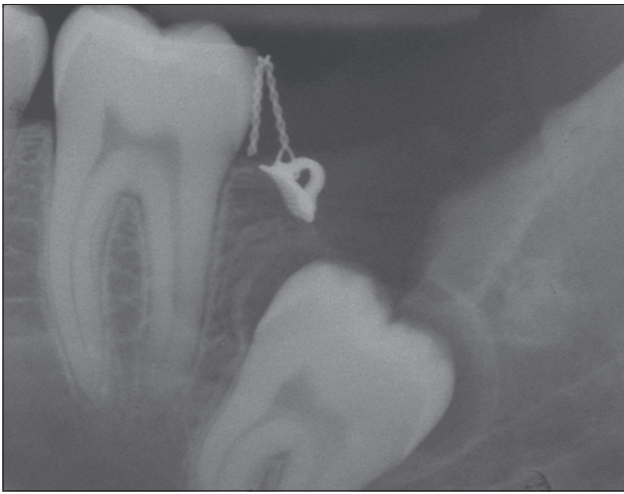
A periapical radiograph taken the day after surgery confirmed the clinical impression of failure of the bonded orthodontic attachment.
